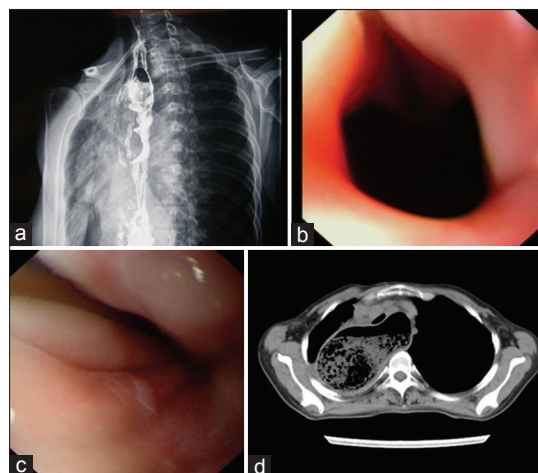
Barium meal X-ray examination showed a dilated esophagus with tapering at the distal end. This tapering is often referred to as “bird’s beak appearance” and is typical of achalasia and a large area of patchy shadows on the right chest (a). On upper gastrointestinal endoscopy, the inner diameter was expanded obviously of the upper esophagus (b) and the scope could not be moved beyond the gastroesophageal junction (c). A 16-slice computed tomographic plain scan showing the upper esophagus expanded obviously (d).
